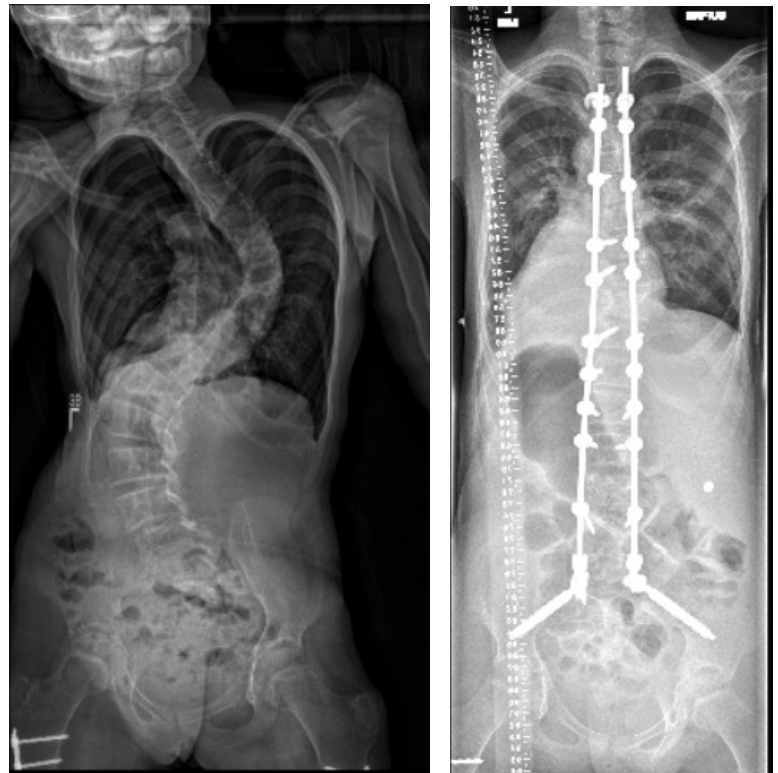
PA radiographs of a 10-year-old girl with Marfan syndrome demonstrating pronounced scoliosis at a relatively young age before (a) and after (b) posterior spine fusion with a long construct that extends to the pelvis and includes all curves. Spine dysplasia is characterized by narrow, dysplastic pedicles, wide transverse processes, and short-segment scoliosis.
